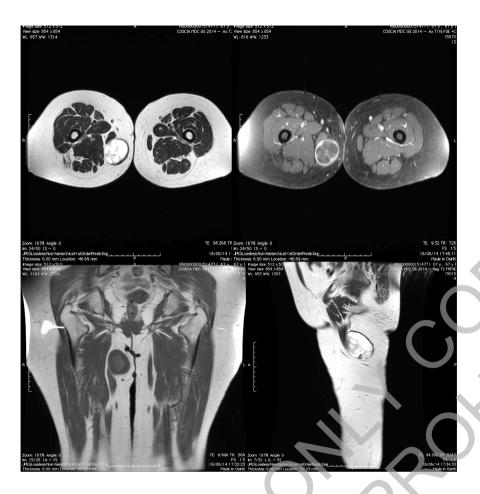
MRI with contrast: the images show the encapsulated cystic lesion, with multiple septa and a maximum diameter of at least 5.6 cm, lying in subcutaneous tissue over the gracilis and adductor magnus muscles without signs of infiltration. The capsule signal enhanced after gadolinium administration.
